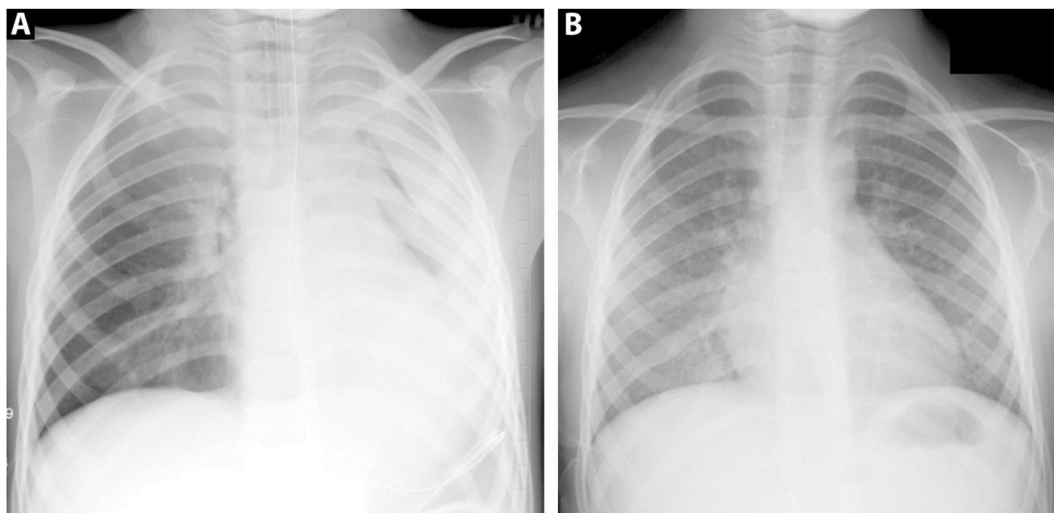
A) Chest x-ray at presentation, and B) Chest x-ray prior to home discharge for Case 1.
